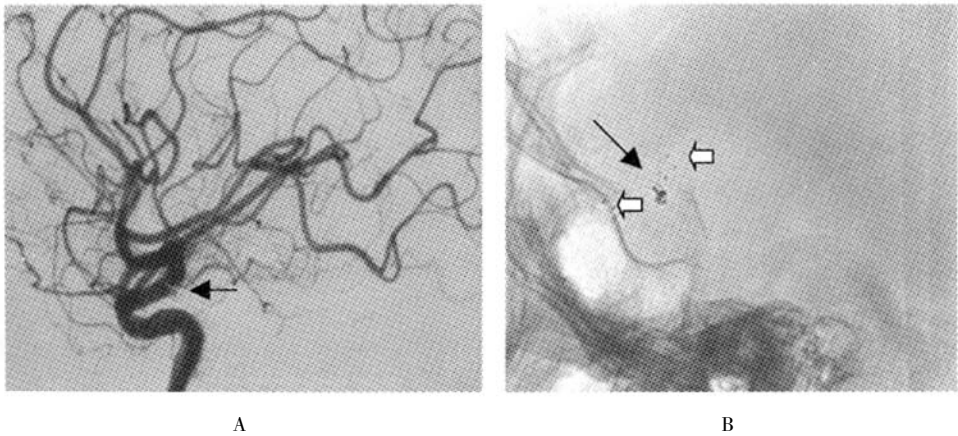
Stent-assisted coiling of the left carotid-posterior communicating artery aneurysm. A. Post-procedure angiography of left carotid artery showed that the small aneurysm was totally occluded (→) with concurrent preservation of the parent artery. B. Lateral plain film showed both ends of the stent (◇) and the two packed coils within the aneurysm. Part of the outboard coil (→) was perpendicular to the long axis of the stent and the outboard coil would later escape from the stent confinement into the branch of left middle cerebral artery.
